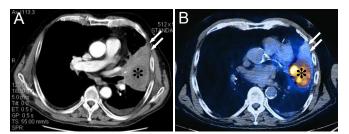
Adenocarcinoma of the left upper lobe in a 67-year-old patient. (A) Contrast enhanced CT shows that the mass (\*) has a wide contact with the pleural surface with a questionable chest wall invasion (arrows). (B) 18F-FDG PET/CT reveals the true tumor extension, no chest wall invasion has been found and the contacting soft tissue density was confidently interpreted as post-stenotic atelectasis (arrows).
